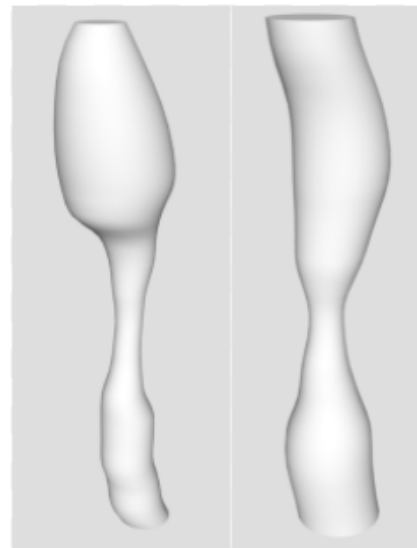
Physical Models. Shown are the physical models produced in Autodesk, created from x-ray images of patients with esophageal stricture
